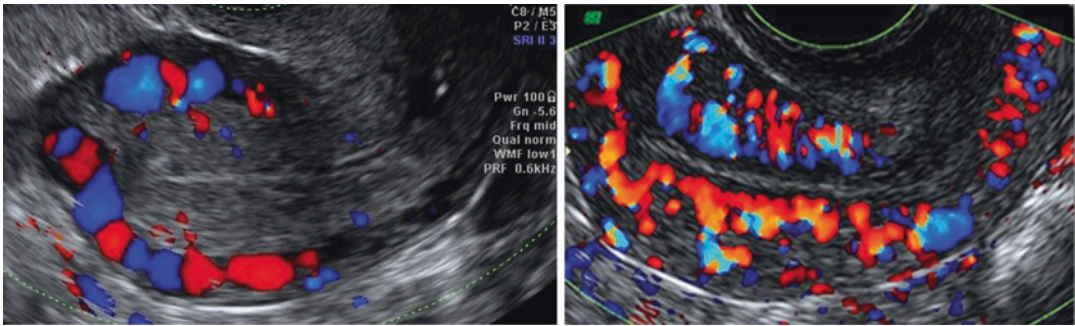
Color Doppler of the normal uterine vascularity (sagittal section): left, the arcuate vessels are more prominent, whereas, right, the radial arteries are visible
